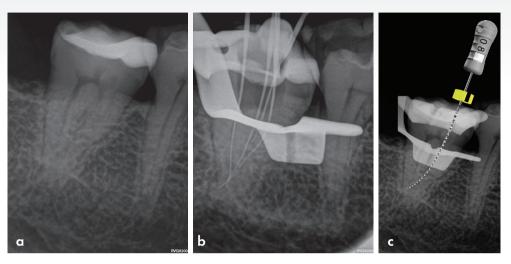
(a) Pre-op peri-apical radiograph of mandibular second molar; (b) Length determination radiograph; (c) A size 08 K-file used for initial canal negotiation
